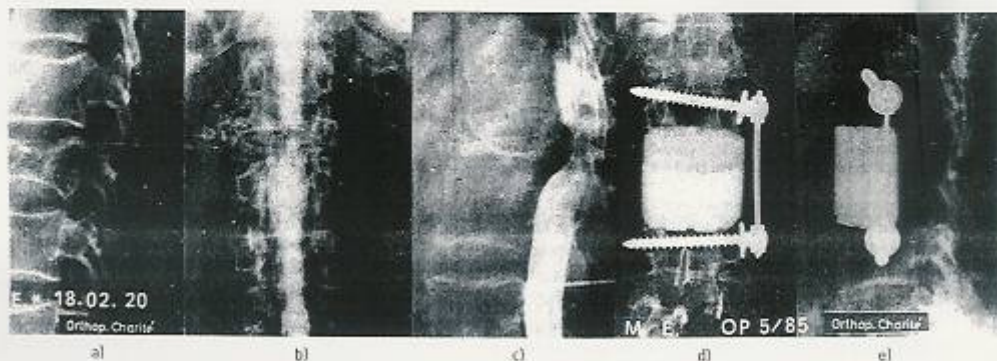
Replacement of a vertebra in a tumor patient with a machinable bioactive glass ceramic (Dr. J. Gummel, Charité der Humboldt-Universität Berlin). a)–c) Different views of the destroyed vertebra; d), e) The vertebral prosthesis (X-ray picture). See text.
